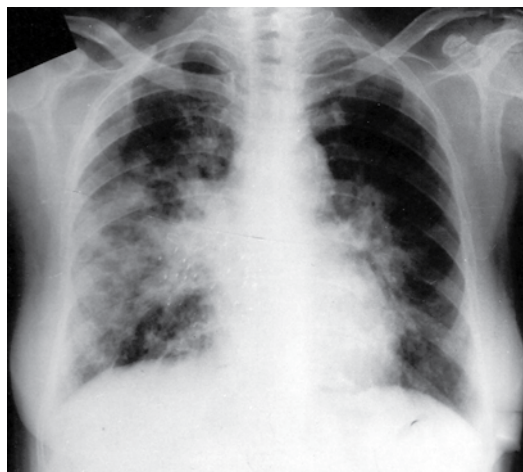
Anteroposterior chest X-ray, taken 9 months prior to referral, showing diffuse, patchy opacities in both lungs, together with bilateral hilar enlargement. An acinar pattern with areas of confluence can be seen in the right middle and lower fields.
